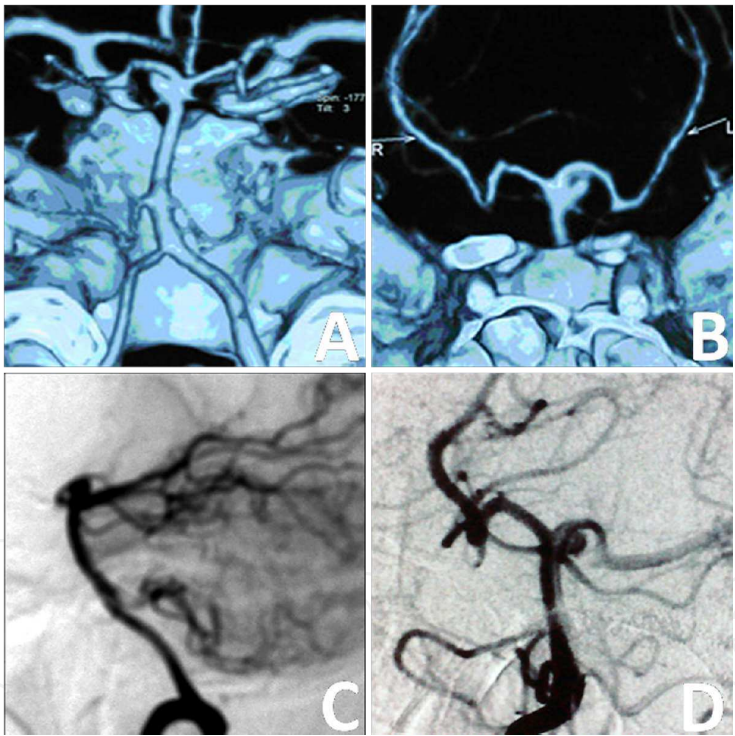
Preoperative angio-CT reconstructions (A,B) and preoperative angiograms (C,D) of an aneurysm of the left PCA/SCA junctional portion of the basilar artery.
